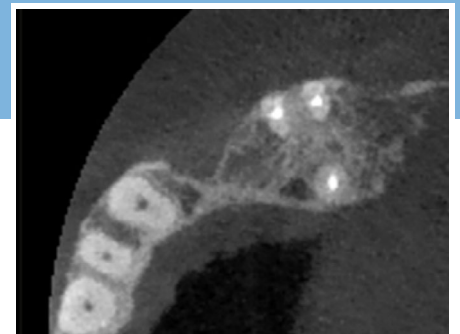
CBCT examination showing horizontal bone loss.
